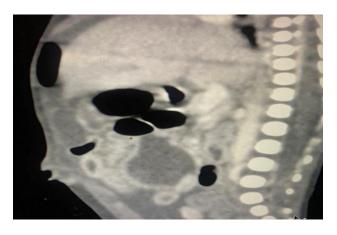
CT abdomen sagittal view showing pneumoperitoneum suggestive of bowel perforation.
